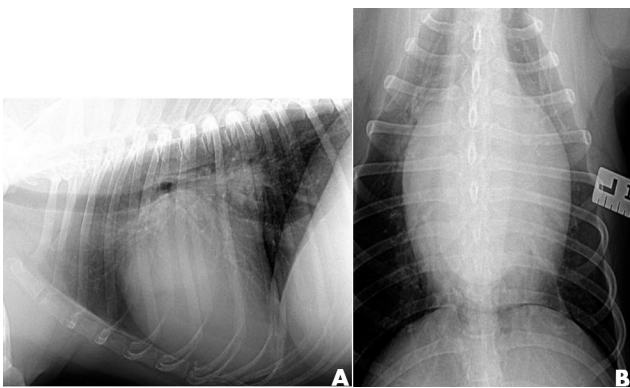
(A) Left-sided cardiomegaly with prominent left atrial enlargement, elevated trachea, and mild alveolar and interstitial patterns in the caudal lung lobes. (B) Dorsoventral radiograph showing left-sided cardiomegaly and severely enlarged left atrium.
